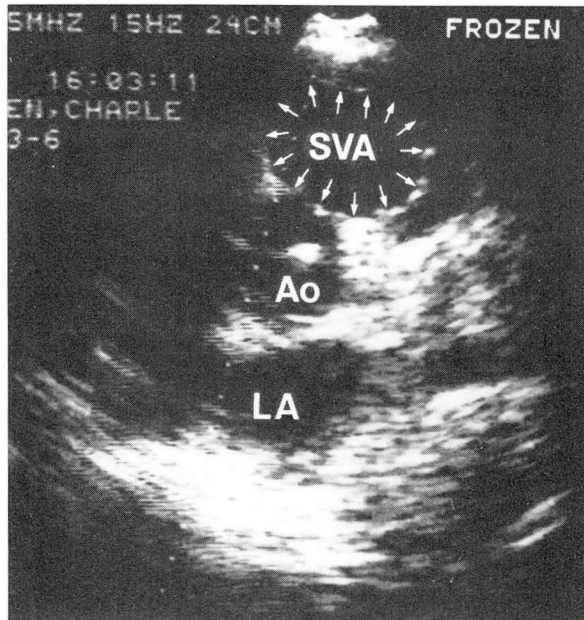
Two-dimensional echocardiogram, short axis view at the level of the aortic valve. Note distinct round mass anterior to the aortic root (*arrows*). (SVA = sinus of Valsalva aneurysm; Ao = aorta; LA = left atrium.)
